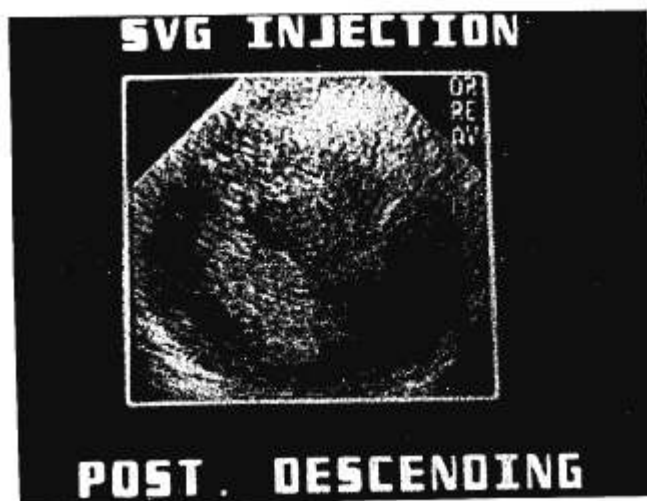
Transesophageal contrast echocardiogram from a patient demonstrating myocardial perfusion during a contrast injection, directly into the proximal end of a posterior descending saphenous vein bypass graft (SVG). Shaded areas represent regional blood flow. POST = posterior.
